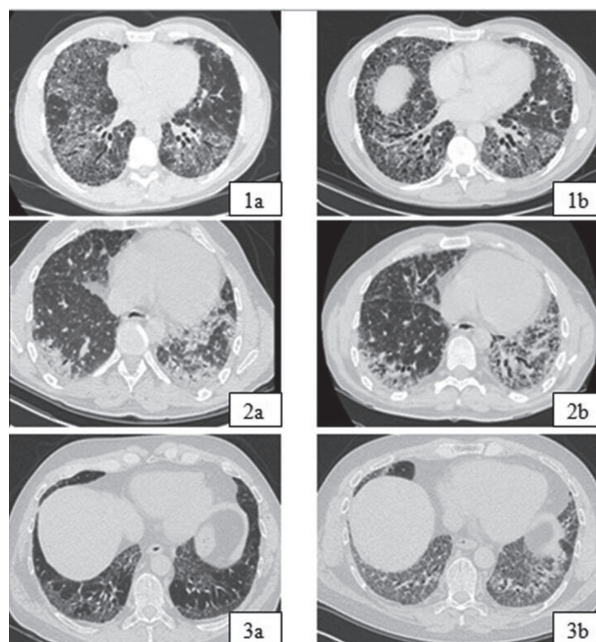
HRCT at presentation (a) and at the time of AEILD (b).
